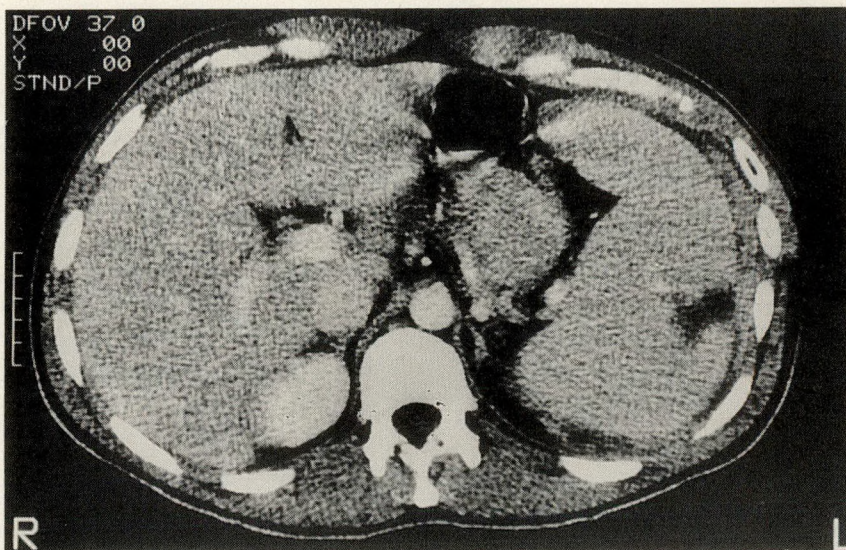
Case 2. Computed tomography scan of abdomen demonstrating splenomegaly, large laceration of spleen and intraperitoneal blood.
